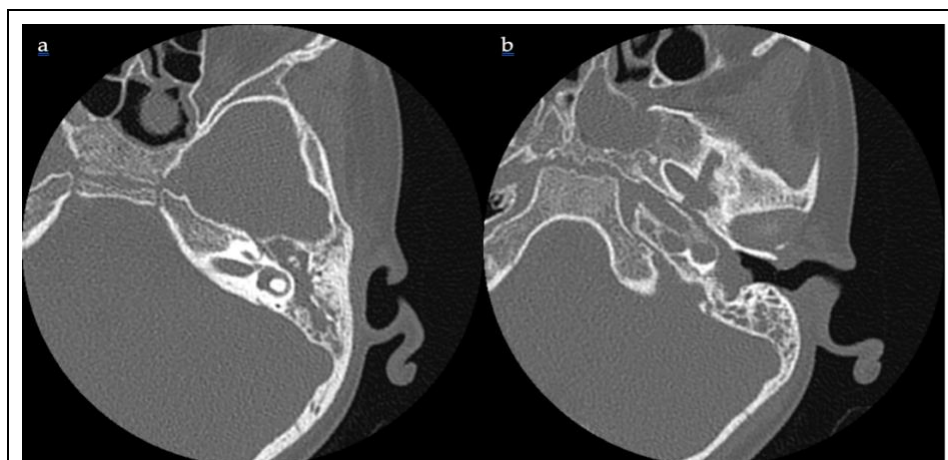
(AB): Cone-Beam CT scan of the left temporal bone displaying complete filling of the left middle ear cavity (a) and mastoid (b) with a soft tissue density mass.
